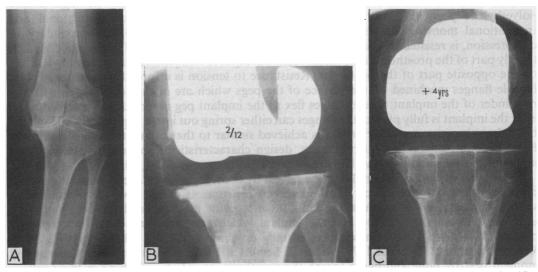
Roentgenograms of a 72-year-old woman with osteoarthrosis who had a left knee replacement in 1977. A, preoperative, demonstrating marked varus deformity. B, two months postoperative macroradiogram of replaced knee. C, four years postoperative; allowing for a difference in roentgen penetration, there is no significant change compared with B
